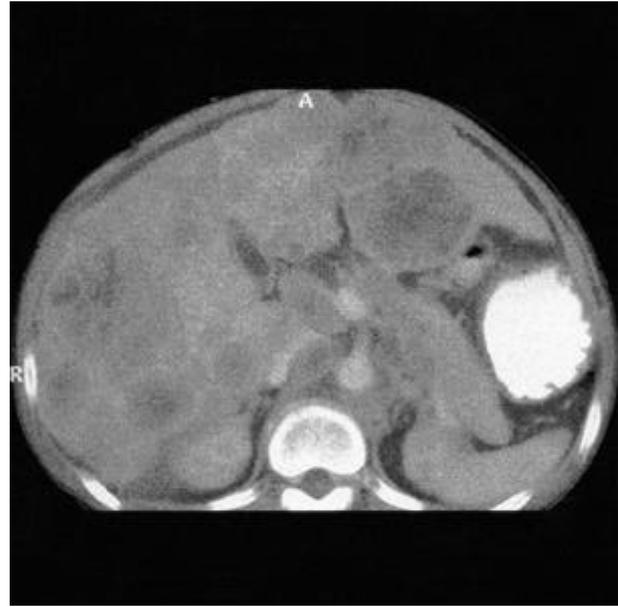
Contrast-enhanced abdominal CT scan shows relatively sharp margined hypodense masses with slight peripheral rim enhancement in both lobes of the liver. A metastatic periaortic lymph node is noted.
